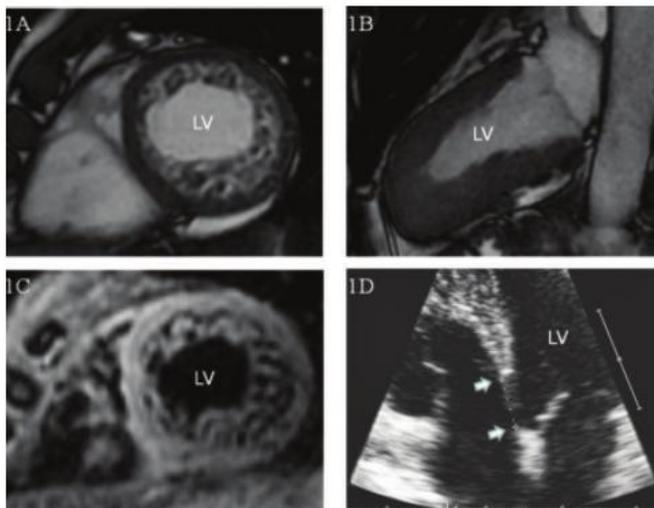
Panel A. Cardiovascular magnetic resonance steady-state free-precession sequence, short axis, showing the presence of an extensive non-compacted myocardial layer lining the cavity of the middle-apical portions of the left ventricle. Panel B. Cardiovascular magnetic resonance steady-state free-precession sequence, long axis, confirming the hypertrabeculation of the middle-apical portions of the left ventricle. Panel C. Cardiovascular magnetic resonance black-blood T2-weighted short inversion-time inversion-recovery, short-axis, confirmed the “sponge-like” appearance of left ventricle myocardium. Panel D. Two-dimensional echocardiography, 4-chambers view, showing the apical displacement of the septal tricuspid valve leaflet (headarrows: distance of 21 mm from the annulus to the septal leaflet insertion). LV=left ventricle.
